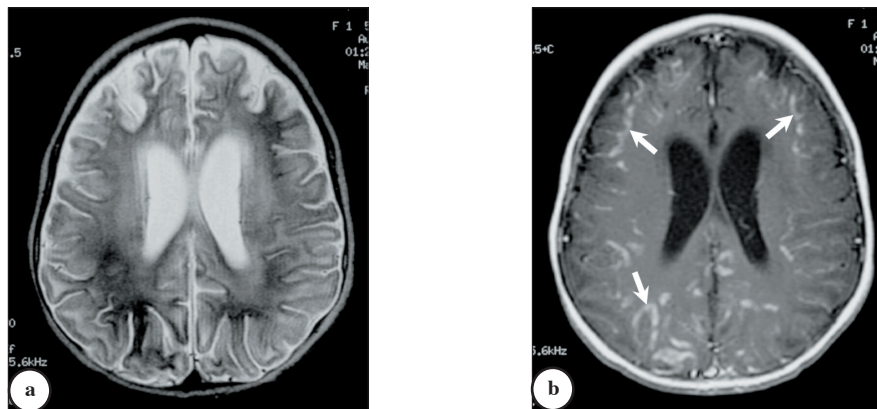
a) Axial T2-weighted MR image of the brain showing cortical and white matter high signal intensity areas due to ischemic insult. b) Enhanced axial T1-weighted MR image showing multiple areas of enhancement at the grey/white matter junction (arrows).
